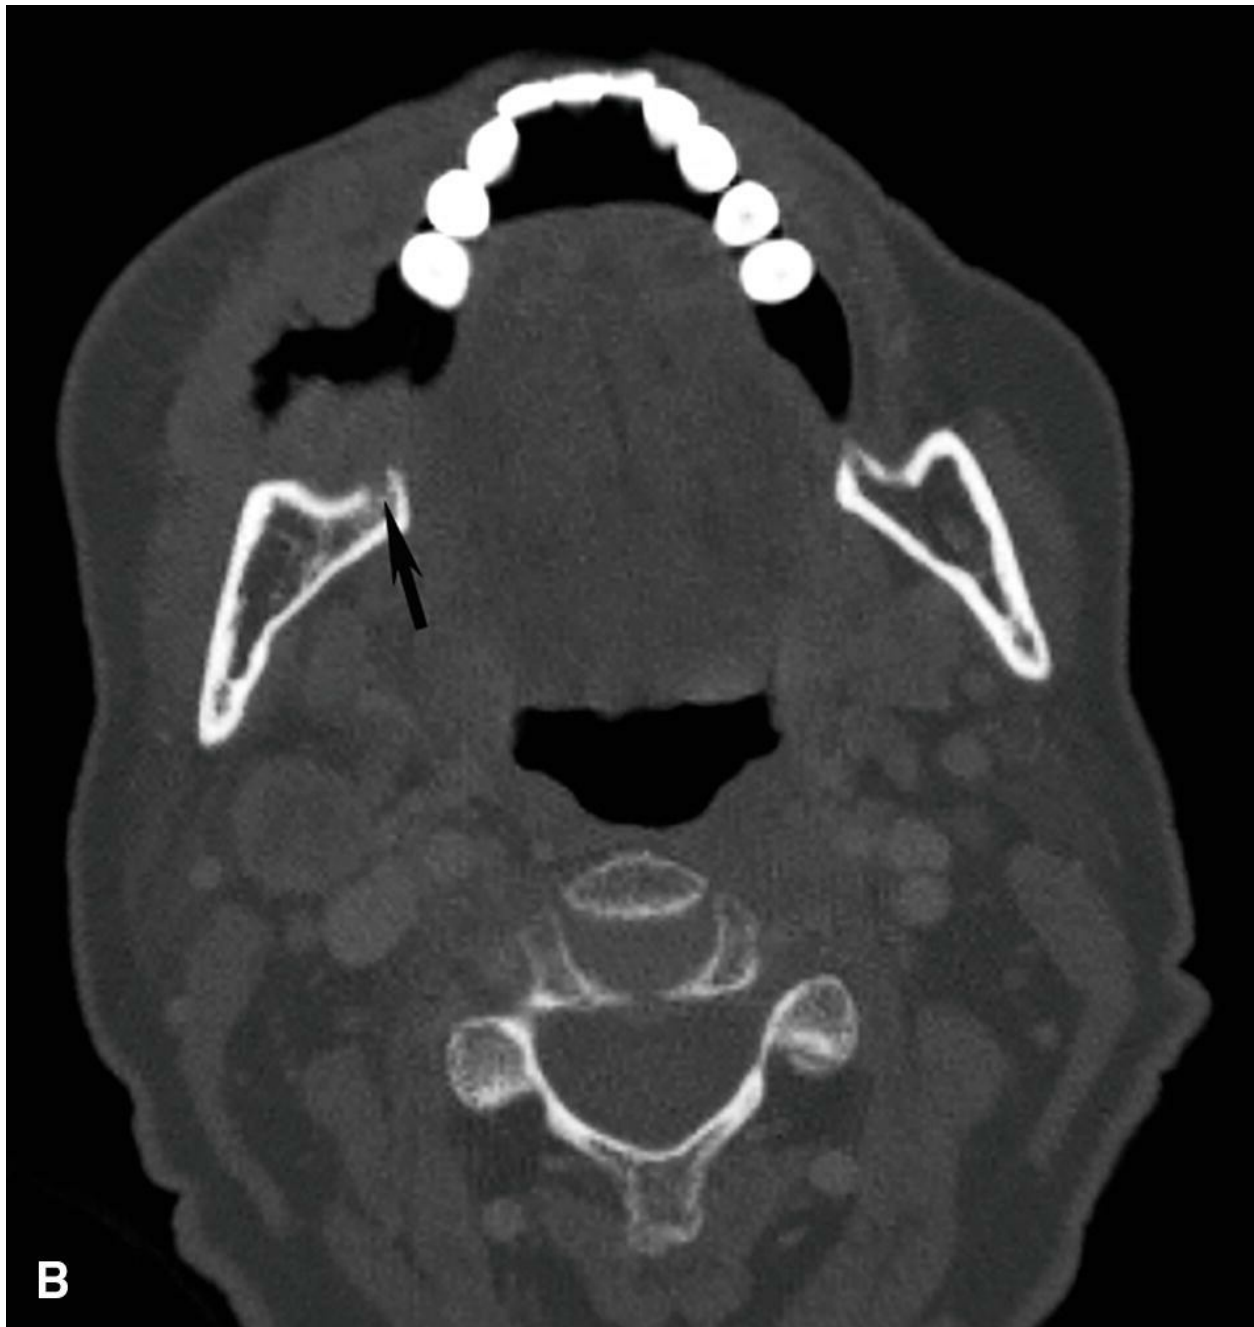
Contrast-enhanced neck CT for tumor evaluation and delineation. Axial contrast-enhanced CT image from a 56-year-old woman with a large invasive oral tongue cancer is shown. Because of differences in tumor vascularity compared to normal tissues, contrast-enhanced images are used to
